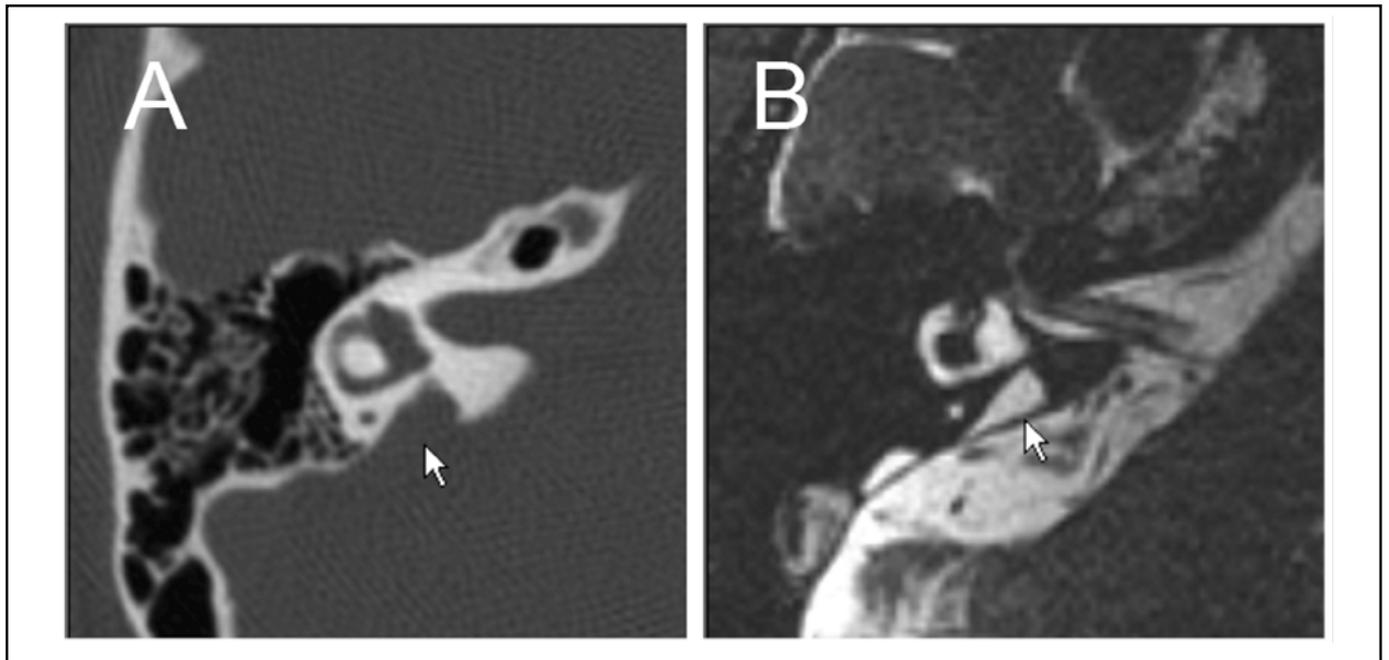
Radiologic imaging of a right temporal bone with an enlarged vestibular aqueduct. (A) Axial computed tomography (CT) scan of an enlarged vestibular aqueduct (arrow). (B) Axial magnetic resonance (MR) image of the same ear showing an enlarged endolymphatic sac and duct (arrow). Reproduced from <http://www.nidcd.nih.gov/health/hearing/eva-intro.htm>.
